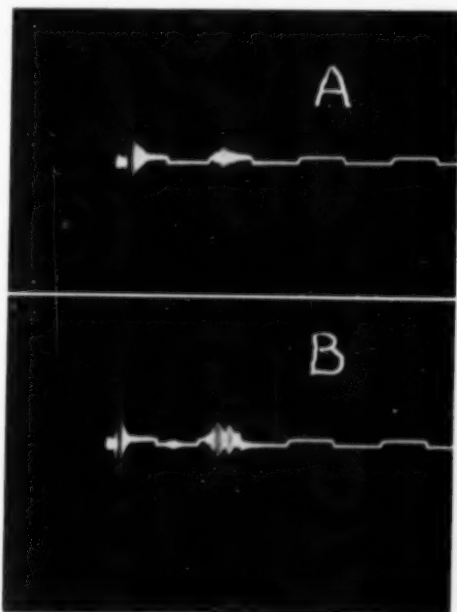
(Mundt and Hughes). Ultrasonic tracing using technique outlined in Figure 21. (A) Normal eye. (B) Opposite eye containing a large retinal detachment.
